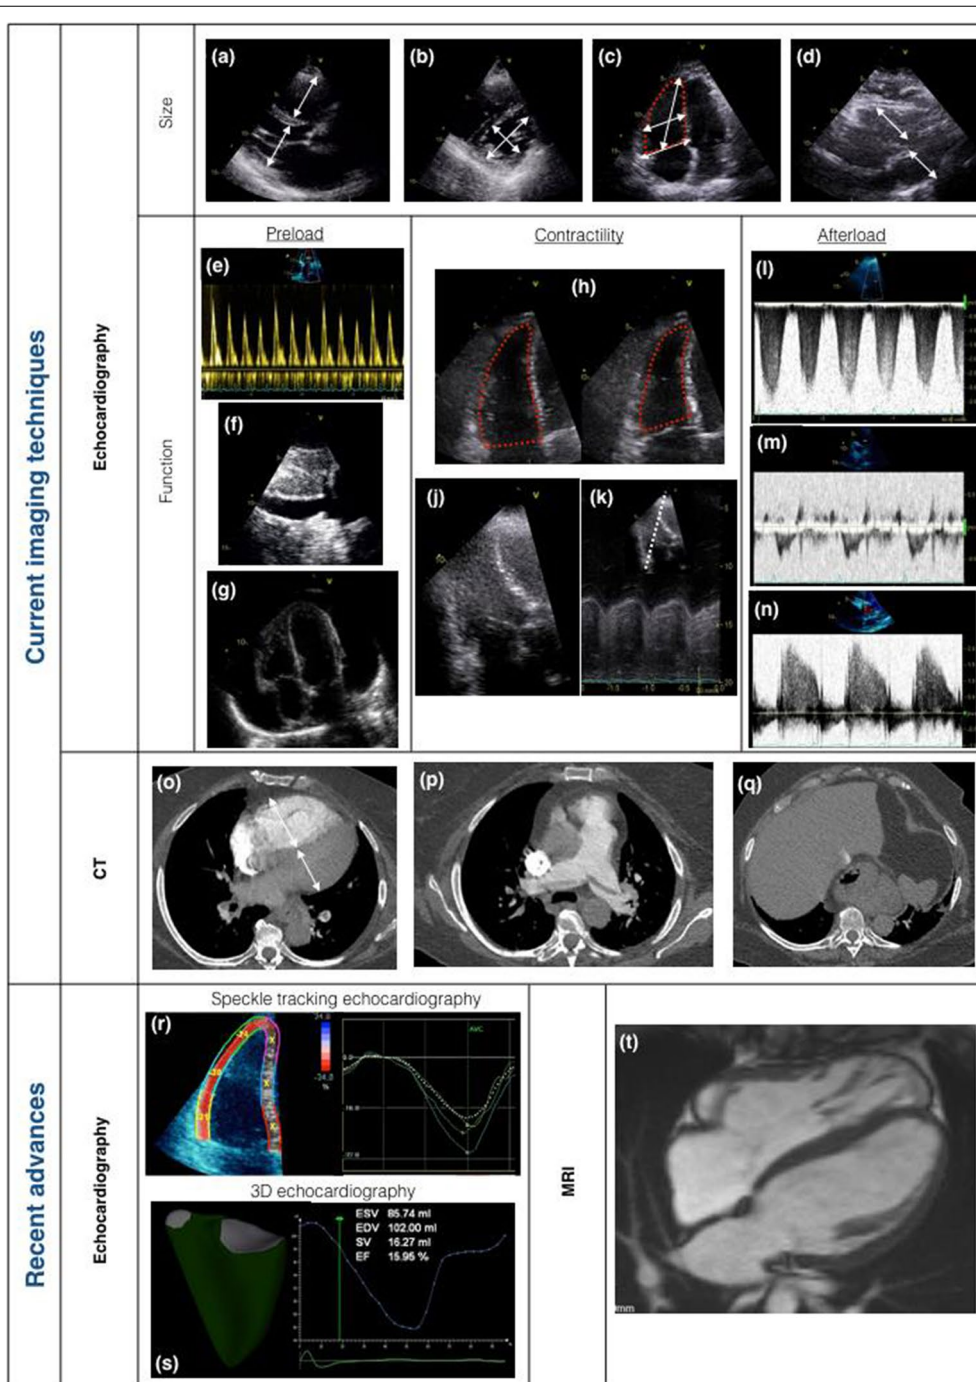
Current imaging techniques in acute right ventricle (RV) failure diagnosis and recent advances. Echocardiography: panels a–n. All view needs to be used to assess RV size and RV function, a parasternal long axis view, b parasternal short axis view (including eccentricity index in assessment of ventricular interdependence), c apical four chamber view (dimensions and area may be useful particularly if the LV is dilated), d subcostal view. Preload analysis: e assessment for fluid responsiveness by stroke volume variation with respiration \pm passive leg raise, f IVC size variation with respiration (less accurate in presence of RVF and significant tricuspid regurgitation), g presence of pericardial effusion. Contractility assessment: h fractional area change, j subjective analysis, k TAPSE (tricuspid annular plane systolic excursion). Afterload assessment: l tricuspid regurgitation jet used for estimation of peak systolic pulmonary artery pressures ($4[\text{TRV}_{\text{max}}]^2 + \text{right atrial pressure}$), where TRV_{max} is the maximal velocity of the tricuspid regurgitation, m RV outflow tract flow analysis (e.g.: “flying W sign” in raised pulmonary vascular resistance), n pulmonary regurgitation flow for estimation of diastolic pulmonary artery pressures ($4[\text{PRV}_{\text{end-diastolic}}]^2 + \text{RAP}$), where PRV is the velocity of the pulmonary regurgitation. Computed tomography (CT): panels o–q. o LV/RV diameter ratio, p pulmonary artery size and presence of thrombus, q IVC contrast regurgitation in acute RV failure. Recent advances: panels r–t. r Speckle tracking echocardiography, s 3D echo volumetric analysis, t apical dyskinesia by magnetic resonance imaging (MRI) due to pulmonary embolism Image courtesy of Dr. Faraz Panthan
